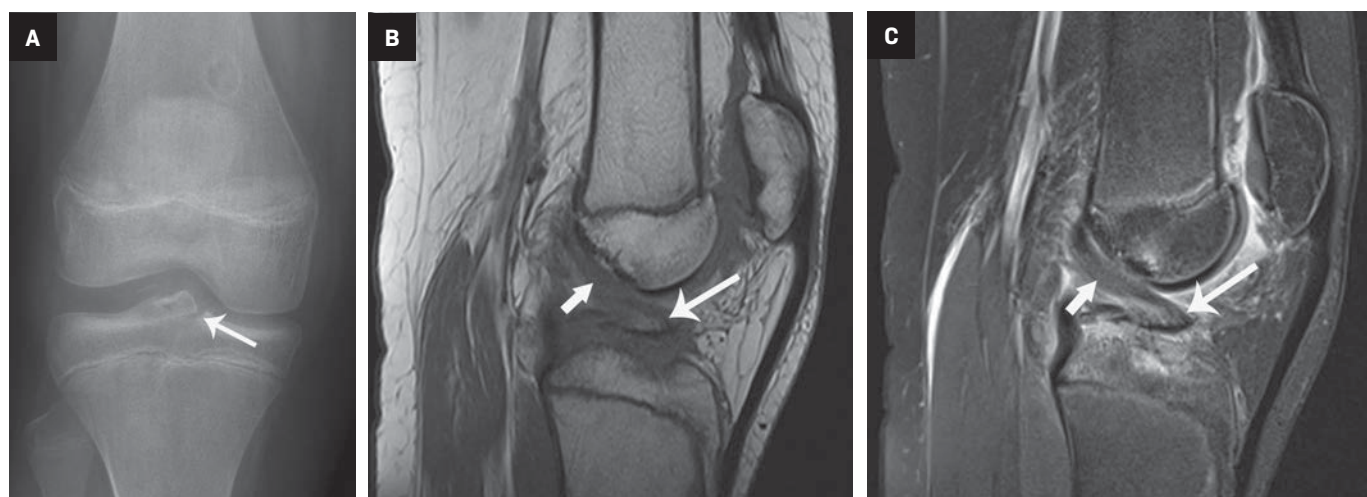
Tibia spine fracture. (A) AP radiograph shows a mildly displaced transverse acute fracture at the tibial spine region (arrow) of the proximal tibial epiphysis in a skeletally immature patient. There is also a nonossifying fibroma incidentally noted at the distal femoral metadiaphysis. (B) Sagittal T1 and (C) sagittal T2 fat-saturated MR images show the anterior cruciate ligament (short arrow) attached to the avulsed tibial spine fracture (long arrow) with associated bone marrow edema.
